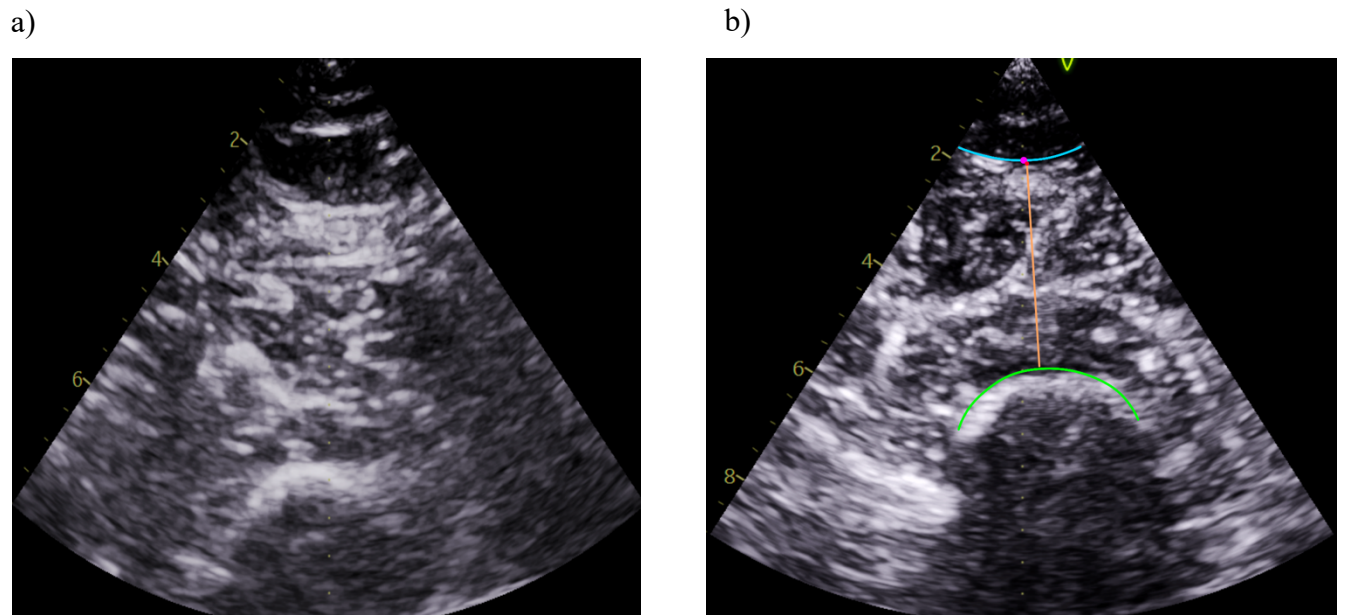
Sample ultrasound images of the quadricep (a) without annotation and (b) with annotations. The green line delineates the top of the femur, the blue line delineates the top of the quadricep muscle, and the orange line connects two points, providing a muscle thickness measurement.
